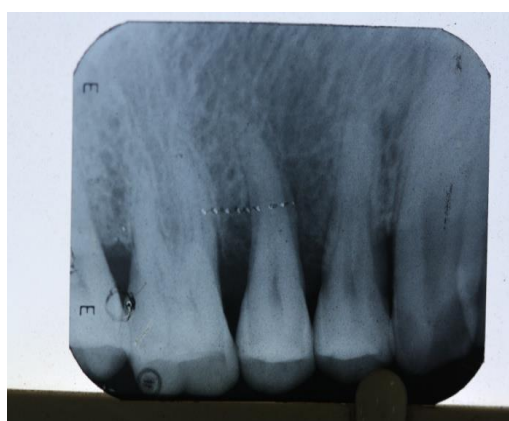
Radiographic 6 month Follow Up of Case I
